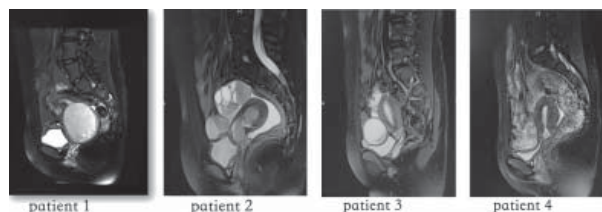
Magnetic resonance images of the four patients
